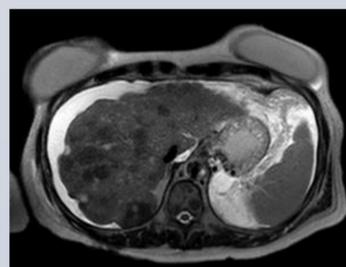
MRI axial T2 image of a patient with metastatic breast cancer treated with chemotherapy showing multiple hepatic metastases with pseudocirrhotic changes.
